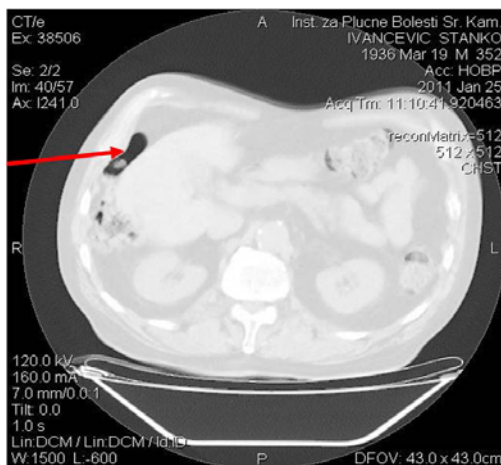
Computed tomography of the chest verified the Chilaiditi's sign (arrow).
